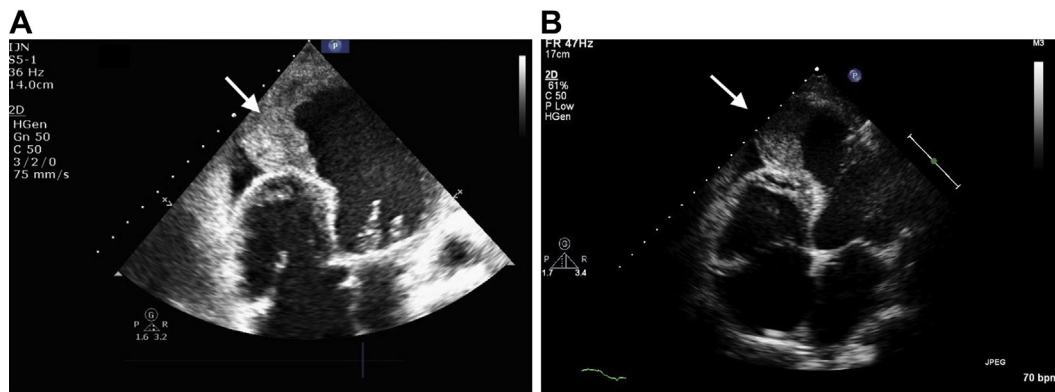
(A) Thick apical aneurysm (*arrow*), expanded and compressing the right ventricular chamber with pulsatile systolic expansion and high echo density suggestive of IDH. (B) Subsequent echocardiography 3 months later showing no significant changes compared to previous echo (*arrow*).
